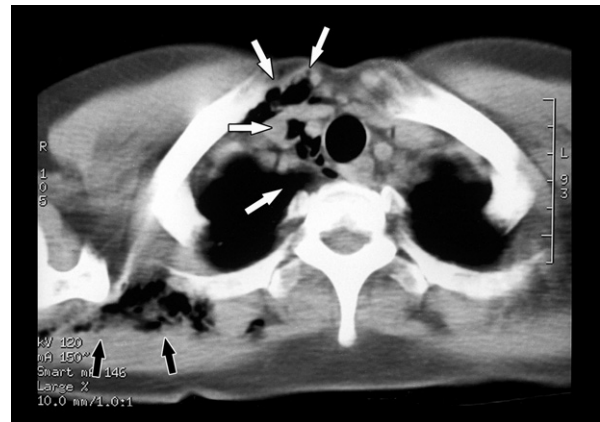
CT scan at the level of the clavicle. Air can be seen in the superior mediastinum (white arrows) and subcutaneous tissue of the back (black arrows).
